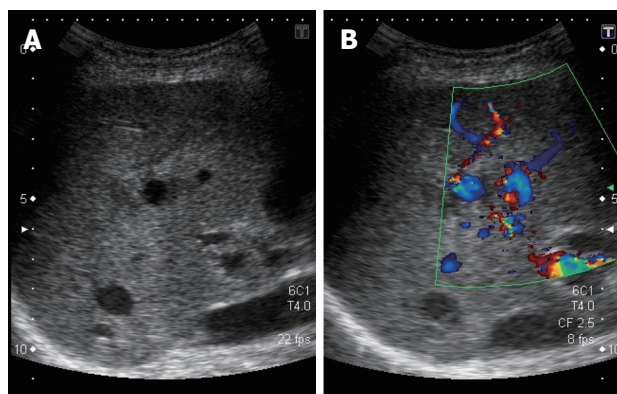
Aneurysm on hepatic Doppler-ultrasound. Sagittal view of the liver representing the aneurysm at the center of the echographic field (A) and Doppler signals confirming the blood flow inside the aneurysm (B). The branch from the hepatic artery the aneurysm is originating from is not seen on the image.
